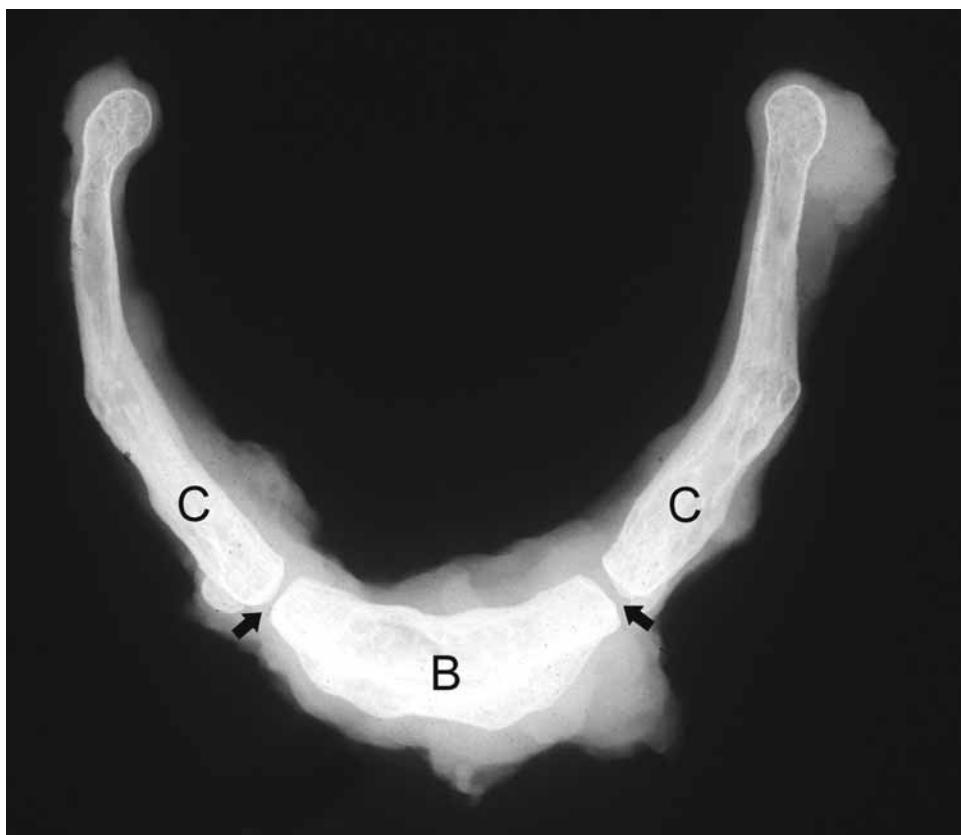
Radiograph of hyoid bone. Body of hyoid (B). Greater horns or cornua (C). Synchondroses (“joints”) not fused (arrows).
